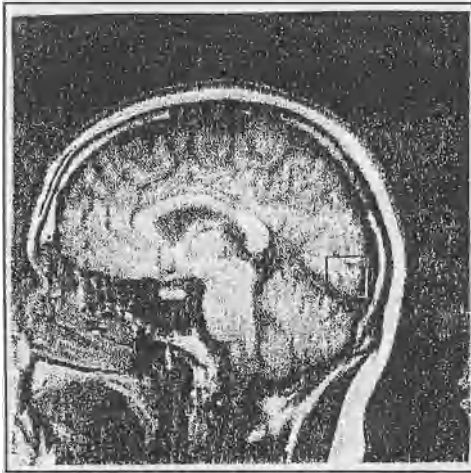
MRI brain image. Sagittal slice near midline
